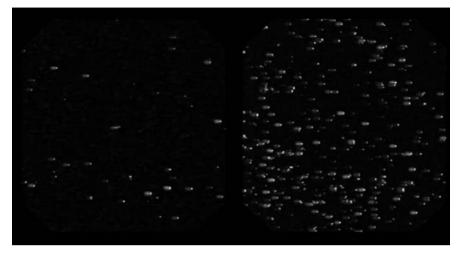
Endoscope images are displayed which were acquired under radiation. Left: Radiation parameters of 84 kV and 1.8 mA were used. The imaging result of increasing X-ray generation parameters (110 kV and 3.0 mA) is shown on the right hand side
